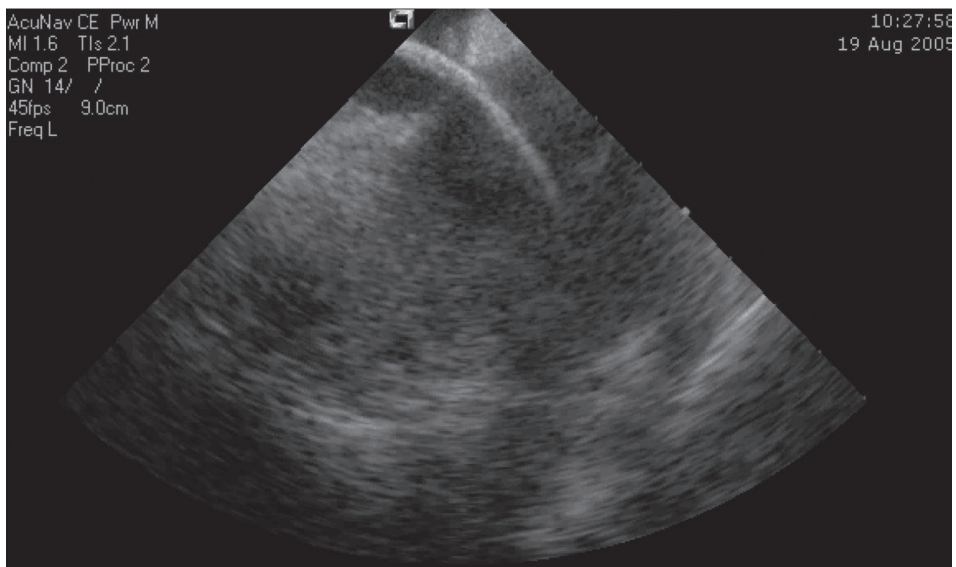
Intracardiac echocardiogram with transseptal sheath from right atrium (upper cavity) through the oval fossa in the left atrium. Attached to the sheath is a small clot, in spite of the administration of 5000 IU heparin before the puncture.
